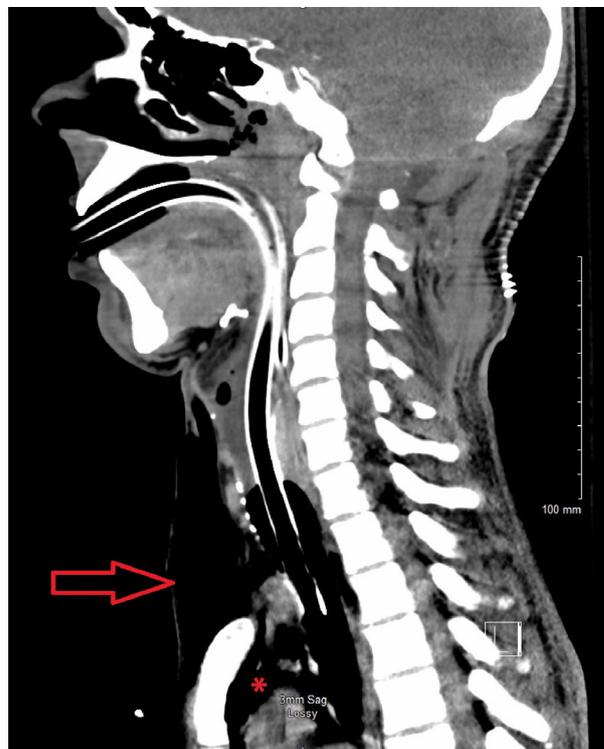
Computed tomography scan of the neck. Sagittal section showing extensive supra-sternal subcutaneous emphysema (arrow) and retrosternal air (asterisk).
